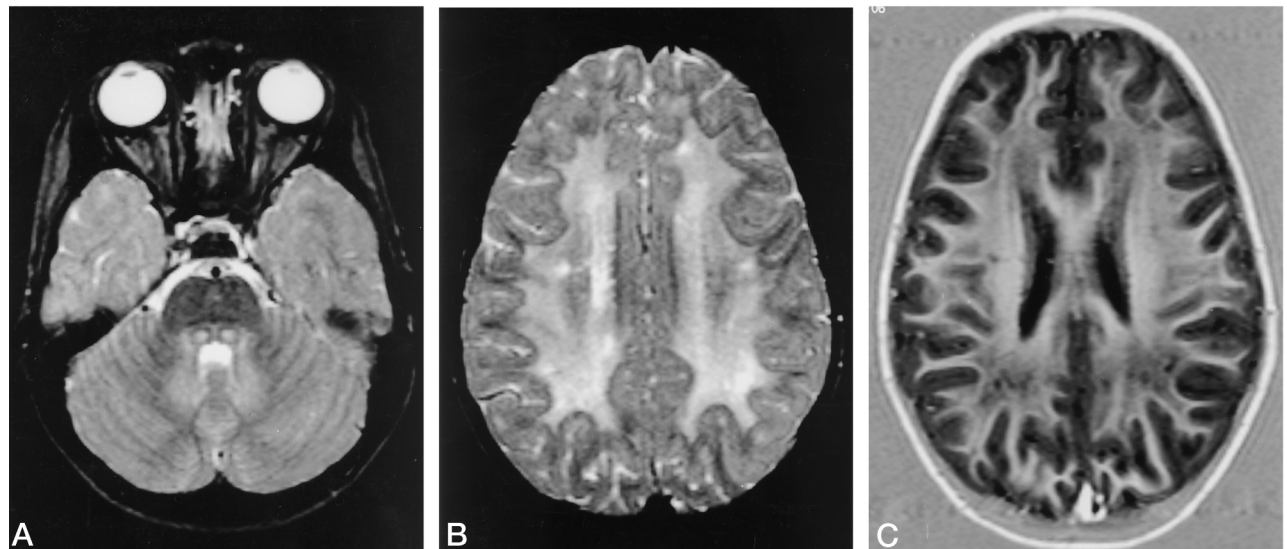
Case 1. Axial T2-weighted (3000/120/1) (A and B) and T1-weighted (4500/20/1; inversion time, 600) (C) MR images show diffuse and multifocal cerebral white matter abnormalities. Two small lesions are seen in the pontine tegmentum (A). The hilus of the dentate nucleus and possibly the dentate nucleus itself have a mildly abnormal signal intensity (A).
